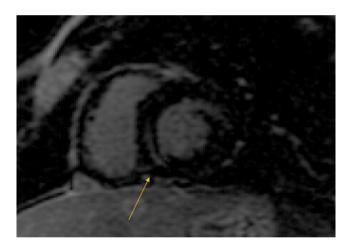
Patient's cardiac magnetic resonance imaging performed during his admission in the pediatric ICU, which shows delayed enhancement in the inferoseptal region. Abbreviation: ICU, intensive care unit
